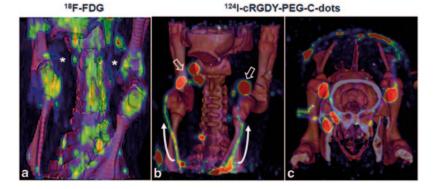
3D integrated 18F-FDG and 124I-cRG-DYPEG-C dot PET-CT. a–c 3D volume-rendered images were generated from CT and PET. (a) PET-CT fusion image (coronal view) shows no evident nodal metastases (asterisks). Increased activity within bony structures
